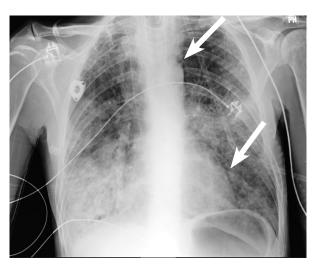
Anteriorposterior chest radiograph displaying lucency adjacent to the aortic knob (arrow) and left cardiac border (arrowhead) consistent with pneumomediastinum.
